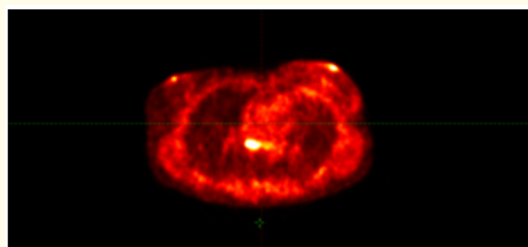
PET CT done before chemotherapy with eribulin.
